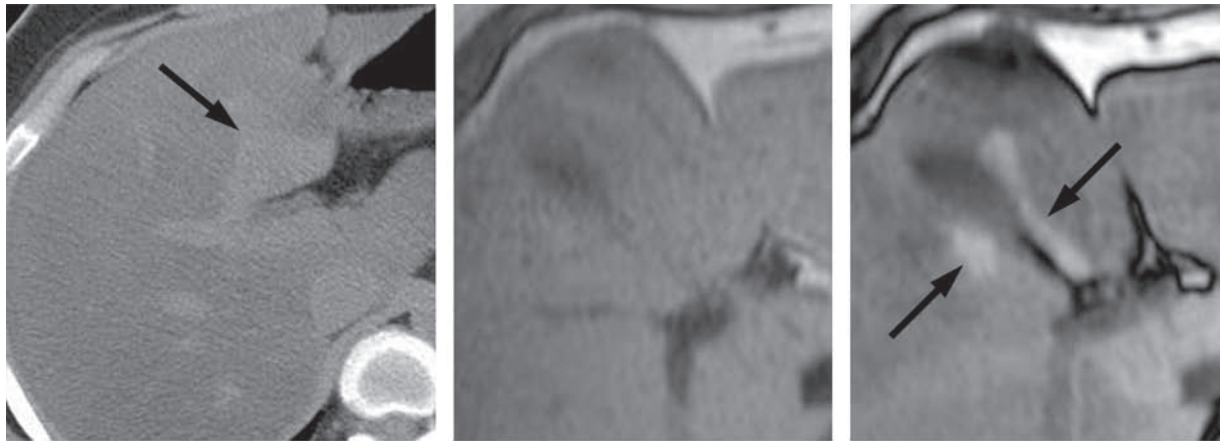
Hepatic venovenous shunt in a 59-year-old woman with portal cavernous transformation caused by recurrent pyogenic cholangitis. Gadolinium-enhanced three-dimensional gradient-echo T1-weighted VIBE MR image (3.8/1.7, 12° flip angle) shows dilatation of the hepatic capsular vein (arrows) as intrahepatic venous collateral vessels.
